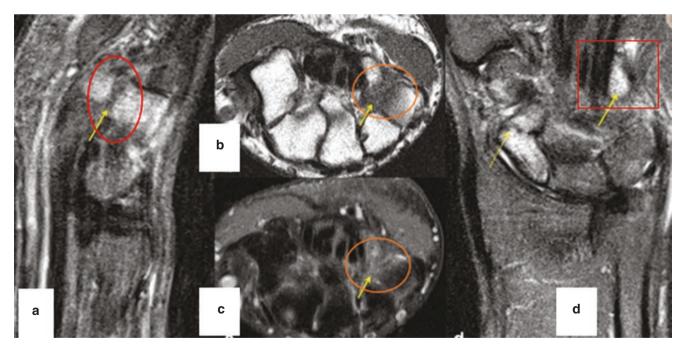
MRI images of hook of hamate fracture and concomitant left scaphoid fracture. (a) Sagittal STIR shows significant marrow edema involving the hook and body of the hamate. (b) Hook of hamate fracture on axial T1. (c) Corresponding axial STIR sequences. (d) Coronal
